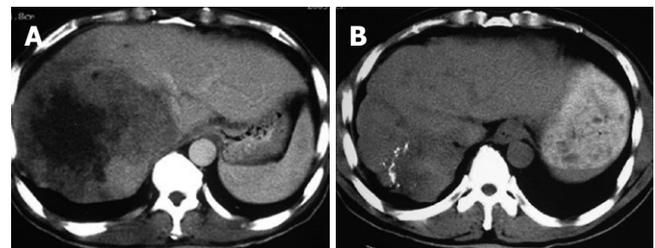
CT of a patient with hepatic colorectal metastases treated by percutaneous cryosurgery. The massive lesion showed a CR to cryosurgery and TACE. A: Before cryosurgery; B: Eight months after cryosurgery and TACE.
